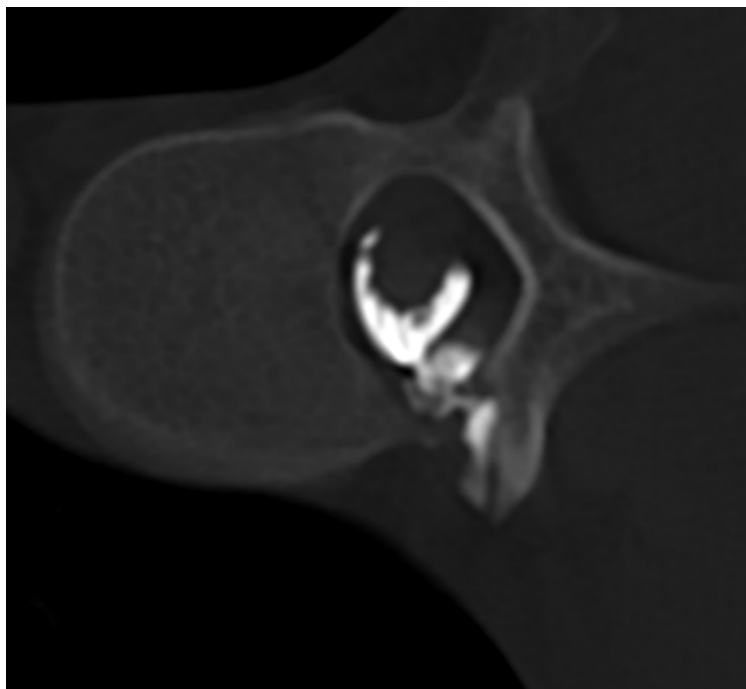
Axial dynamic CT myelography image in right lateral decubitus showing a lateral spinal CSF leak at the T11-T12 level, with active contrast leakage to the epidural space.
